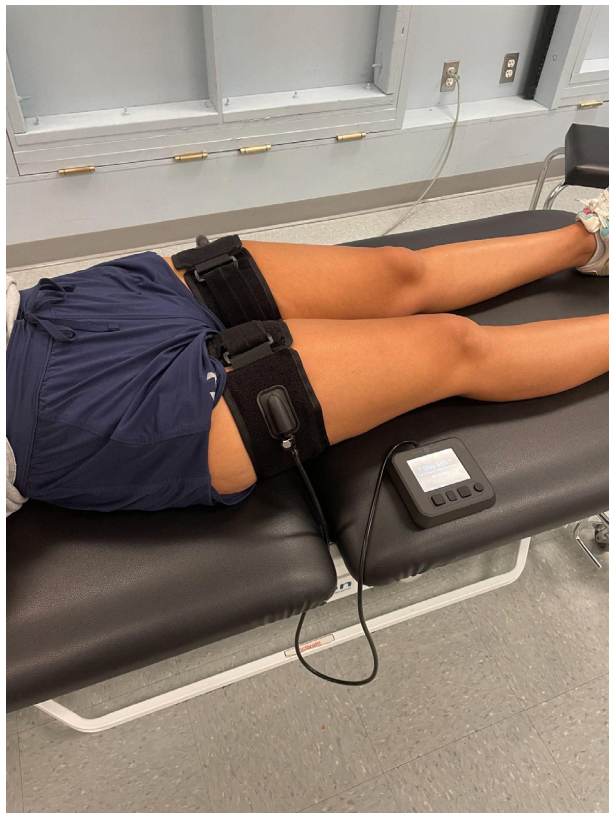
Measuring limb occlusion pressure (LOP) of both lower extremities. This is performed unilaterally at rest. The LOP is then used to determine percent occlusion for exercise. Depending on the blood flow restriction device used this may be calculated through an automated device or may be calculated using blood flow restriction cuffs and a doppler unit.
